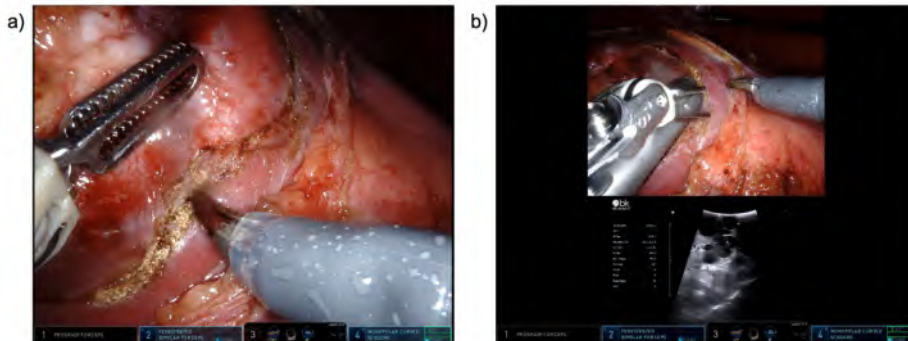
a) tumor delineation by incision of peritumoral tissue. b) endoscopic ultrasound can help guide identification of endophytic tumoral portions.
